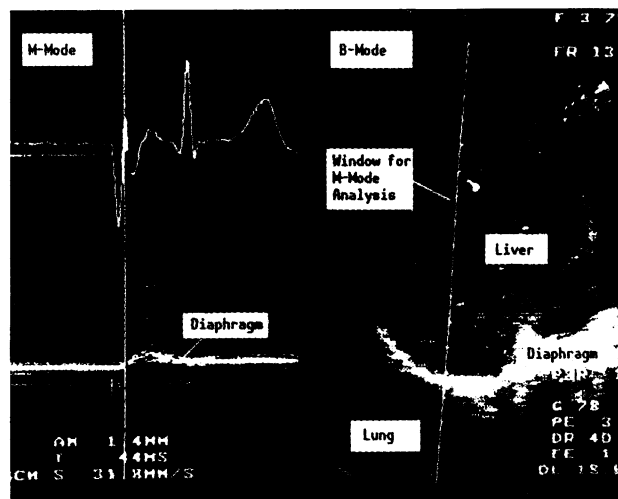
Simultaneous B- and M-mode ultrasound examination. (The line indicates the section at which M-mode analysis is performed).
